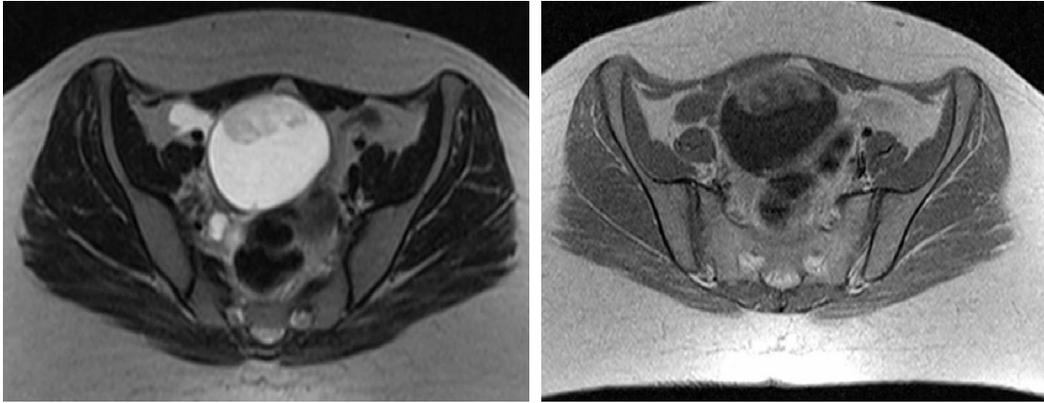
MRI (Axial view) of the pelvis showing right adnexal cystic mass lesion with solid irregular mural component; Borderline papillary serous tumor
